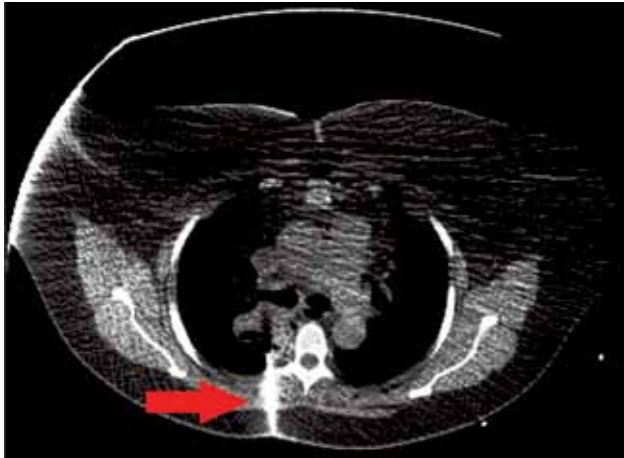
Percutaneous CT-guided core biopsy of the right upper lobe mass with an 18 G needle was performed. The needle can be seen as a bright object inserted posteriorly next to the spine. Though this slice is not at the same level as the section in Fig. 1, comparable sections show that the mass is already improving.
